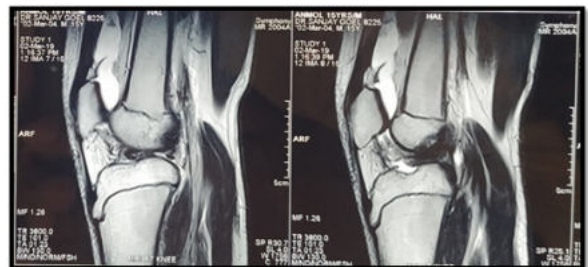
Pre-op MRI Image Showing Avulsion Fracture Of Tibial Insertion Of ACL
